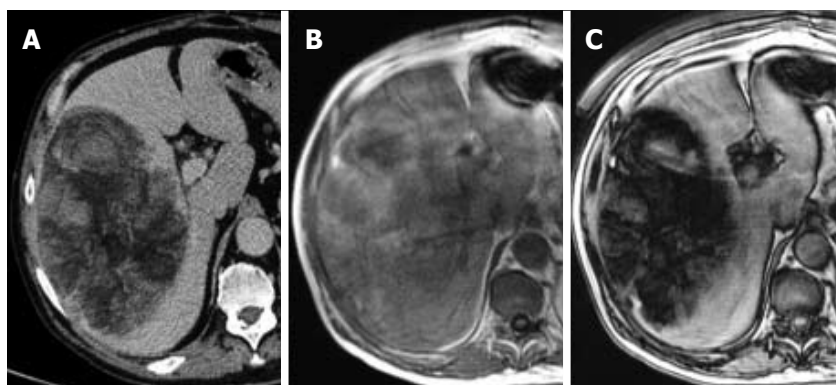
A large hepatocellular carcinoma in the right lobe of the liver demonstrates fat attenuation on non-contrast enhanced computed tomography (A), and loss of signal in the in- (B) and opposed-phase (C) images indicative of fat.
